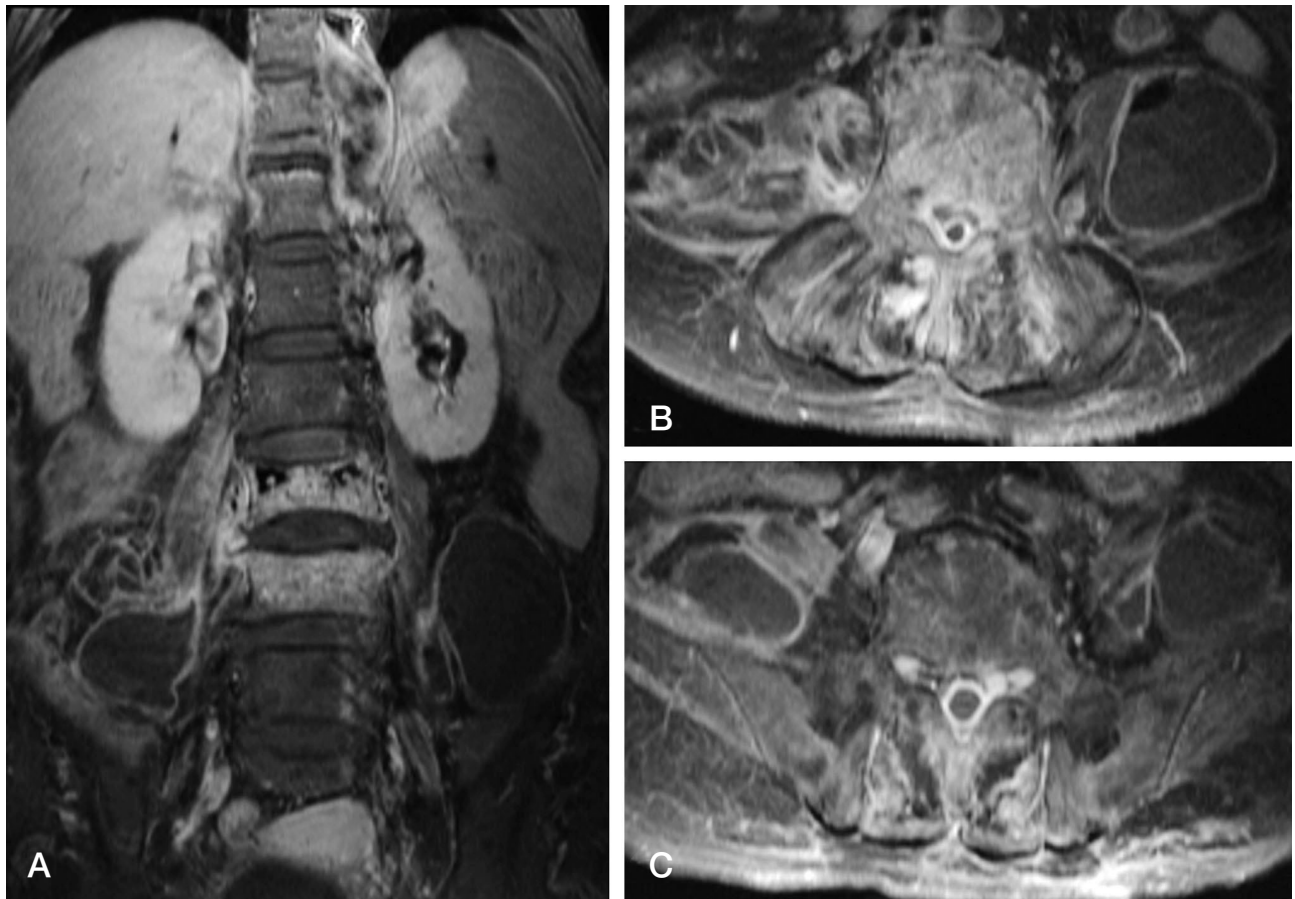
The enhanced T1 weighted coronal MR image demonstrates huge bilateral psoas abscesses with peripheral rim enhancement (A). Also, spinal epidural abscess and pyogenic spondylodiscitis L3-4 was observed. Axial images of L4 level (B) and L5 level (C).
